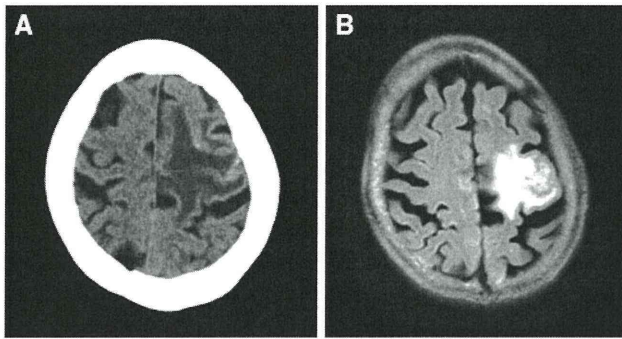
A computed tomographic image 3 months after the first bevacizumab treatment (a) and a FLAIR MR image after 2 cycles of the second bevacizumab treatment (b). A perilesional edema decreased after the second bevacizumab treatment
